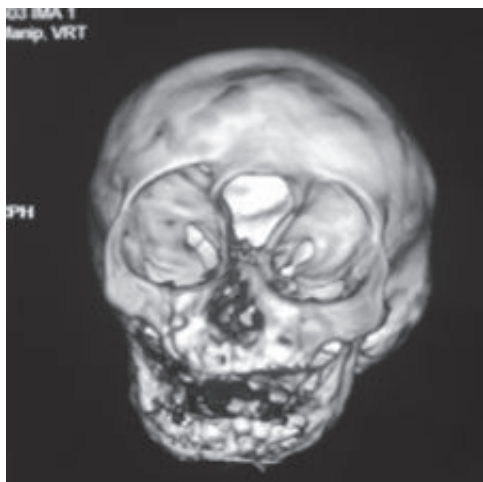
3 D CT scan head external bone defect
